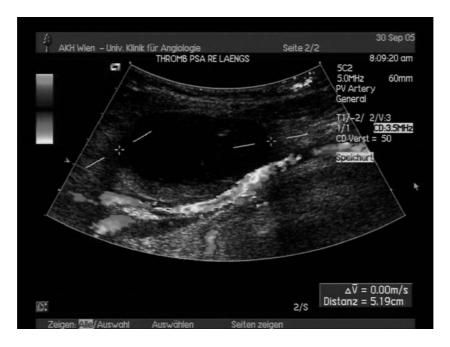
Duplex sonography 10 days after thrombin injection demonstrates complete occlusion of the pseudoaneurysm and regular patency of the common femoral artery.
